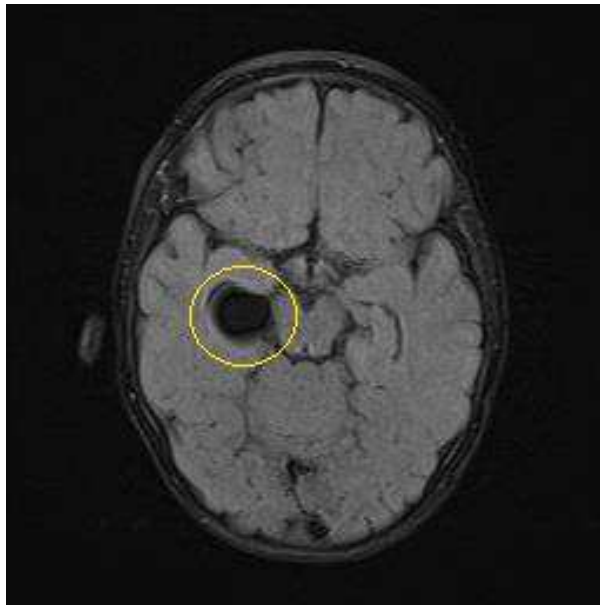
MRI T1 sequence. Axial view. Same cyst in right temporal part.
